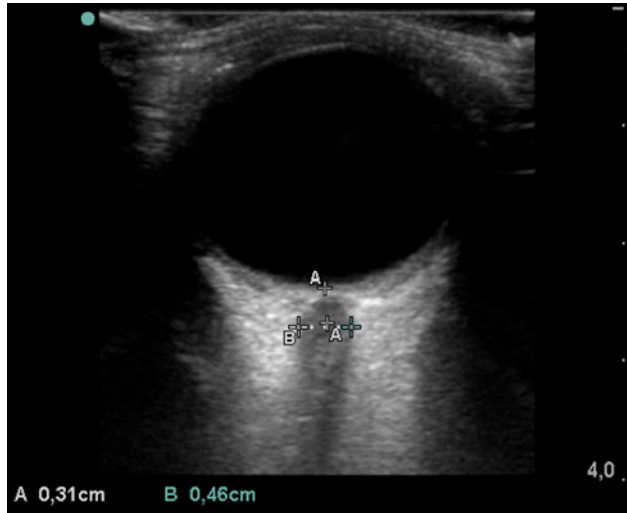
Two-dimensional ocular sonography for measurement of optic nerve sheath diameter. *A* Depth from the retinal to the optic nerve, measured along the axis of the optic nerve. *B* ONSD measured at 3 mm depth, corresponding to the distance between the two external parts of the optic nerve sheath
